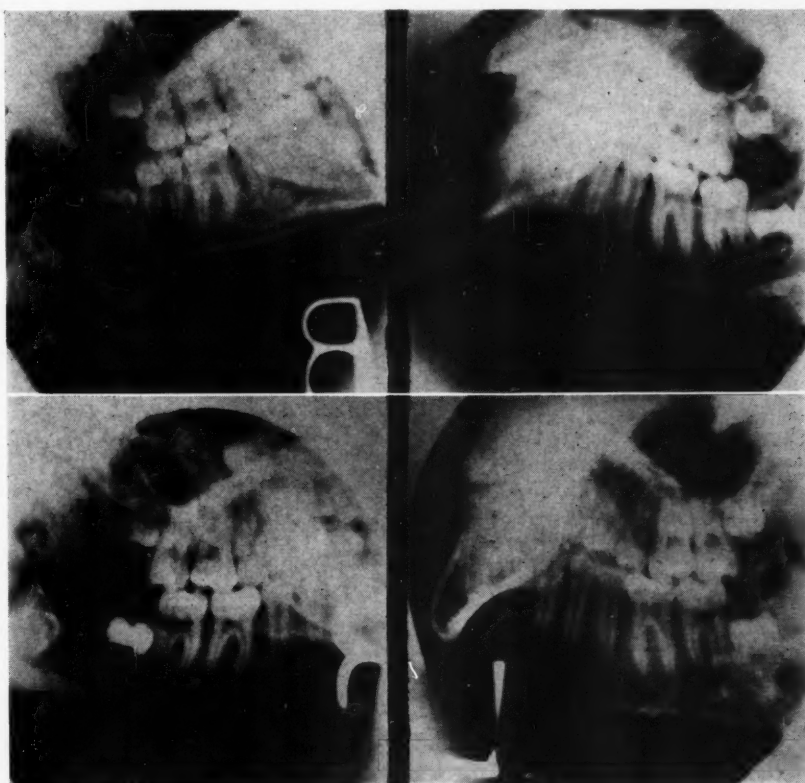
Case 3. X-ray pictures showing molar occlusion (Class II, Division 1, Angle) before treatment and same area with normal molar relationship after treatment. In each instance, a well-developed mandibular molar area indicated a mandible of good size. Though distoclusion in original appearance, it was diagnosed as mesiocclusion of the maxillary teeth (Class II, Division 1, dental) and treated accordingly.
